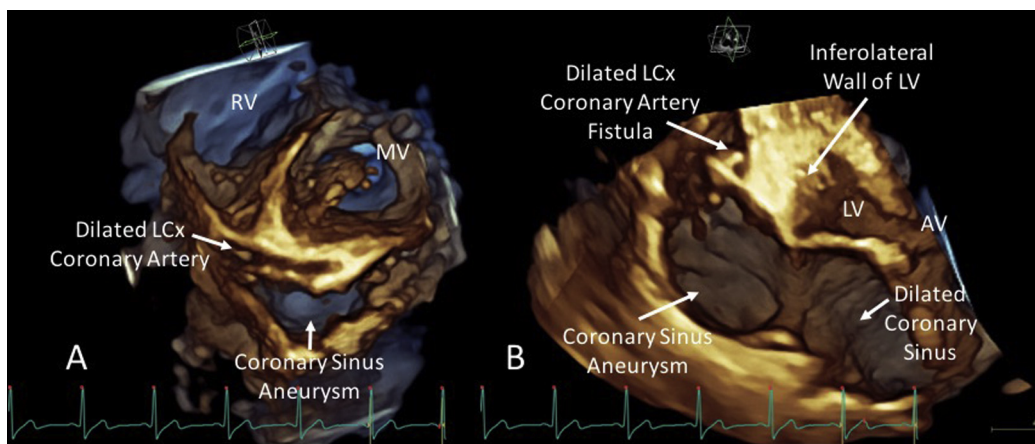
(A) Three-dimensional transthoracic echocardiographic image cut plane through the short-axis view of the left ventricle (LV). (B) Three-dimensional transthoracic echocardiographic image cut plane through the apical long-axis view. AV, Aortic valve; LV, left ventricle; MV, mitral valve; RV, right ventricle.
